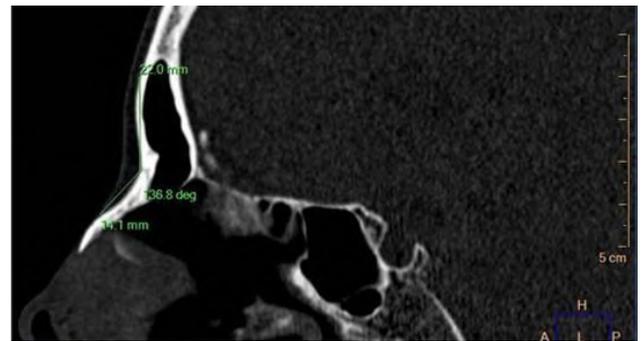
CT scan image of 2D sagittal section showing the measurement of linear distance between the nasion and tip of nasal bone.
